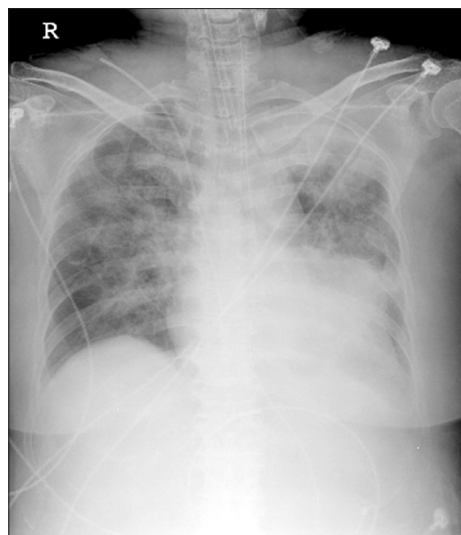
Follow-up chest X-ray revealed significant improvement in the aeration of the left lung.
